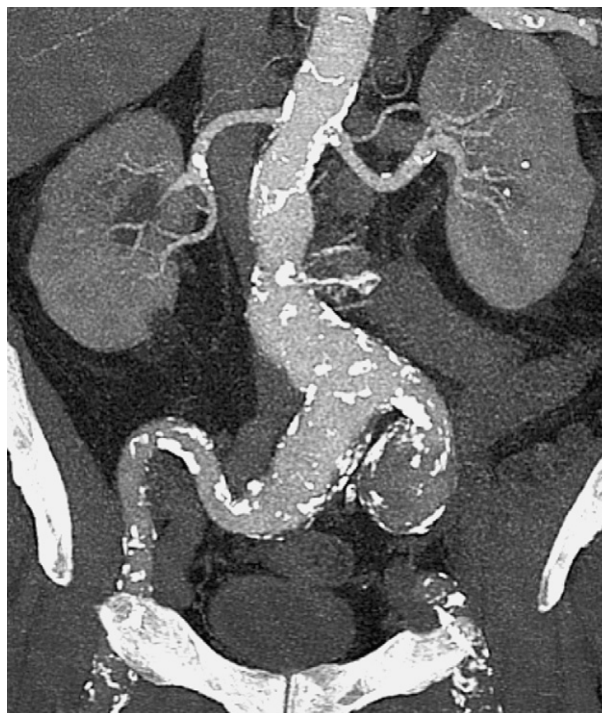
Coronal reconstruction of the preoperative computed tomography scan, showing a bilateral iliac aneurysm. The high diameter of the distal common iliac arteries prevents landing of an endograft.
